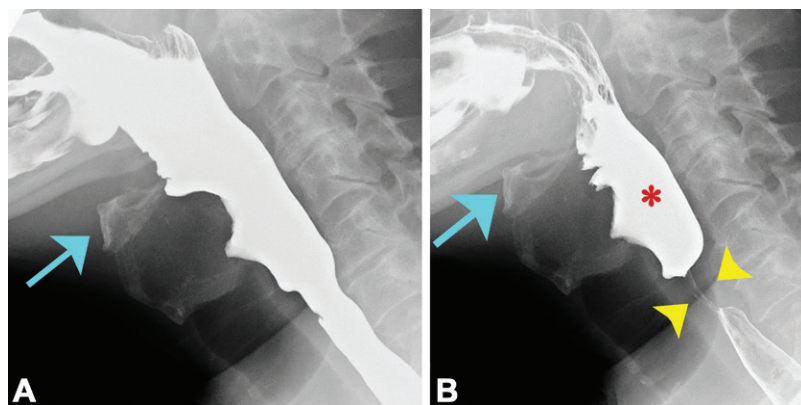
Early closure of the PES due to premature closing of the UES in a 62-year-old man. (A) Lateral radiograph shows a normal PES opening during the passage of the bolus. (B) Delayed lateral radiograph shows an early closing of the PES (arrowheads), while the hyoid bone is still elevated (arrow in A and B). The early closure of the PES interrupts the passage of the bolus, leaving residue in the hypopharynx (*), with increased risk of aspiration.
